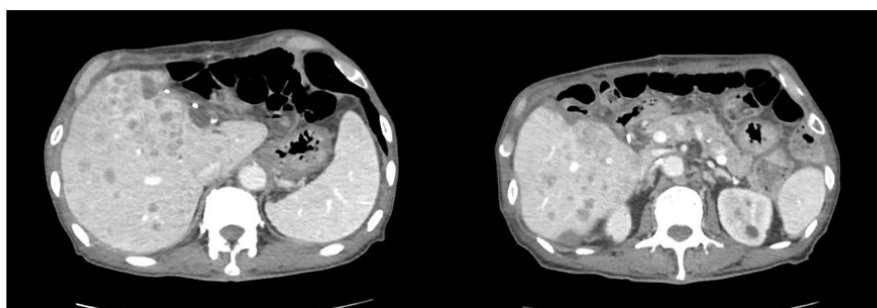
Contrast-enhanced CT 42 days after hepatectomy reveals ascites with multiple recurrent tumors in the residual liver.
